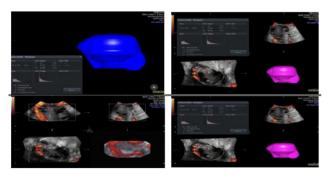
Doppler flowmeter to determine flow index (FI) and vascularization flow index (VFI).
